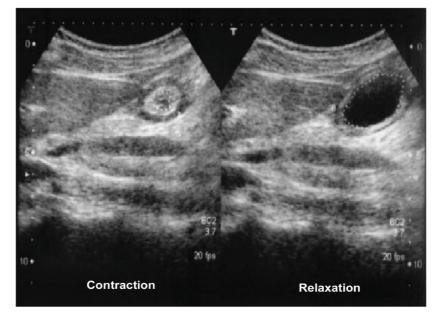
Utrasonographic assessment of antral motility
